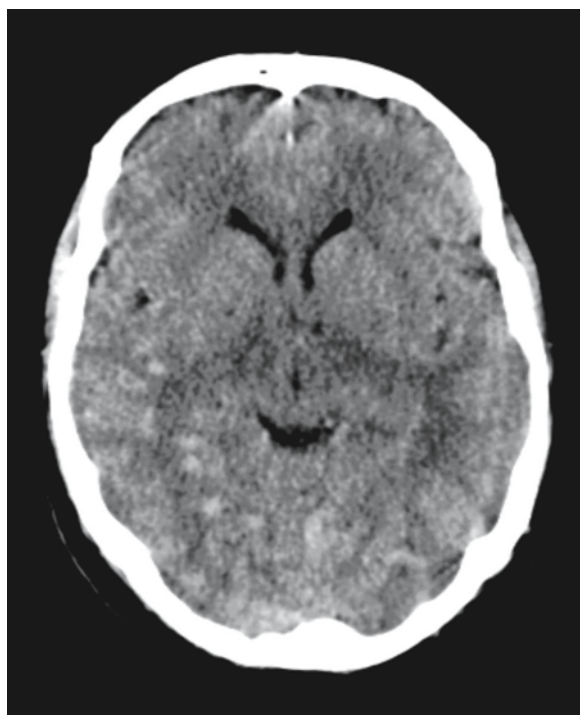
A 57-year-old man presented with rapid cognitive decline related to a DAVF located in the torcular region. On the plain CT scan dilated pial veins are demonstrated in the right temporal region
